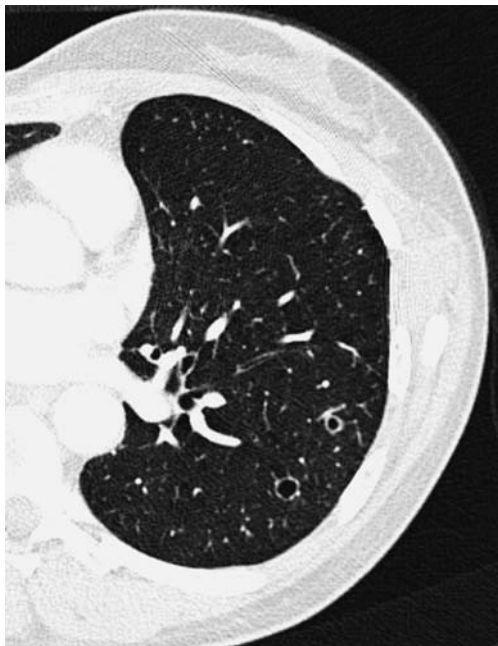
Transverse CT section through the left lower lobe. Recurrence of histiocytosis X in transplanted lung
